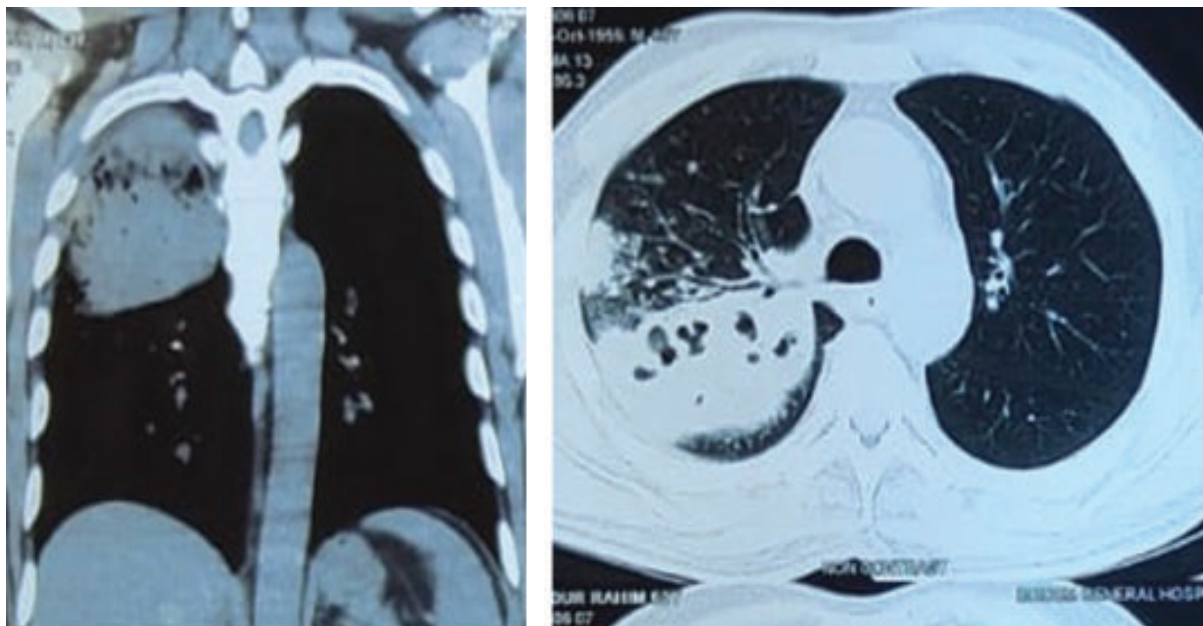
Computed tomography (CT) scan of chest showing consolidation at right upper chest
